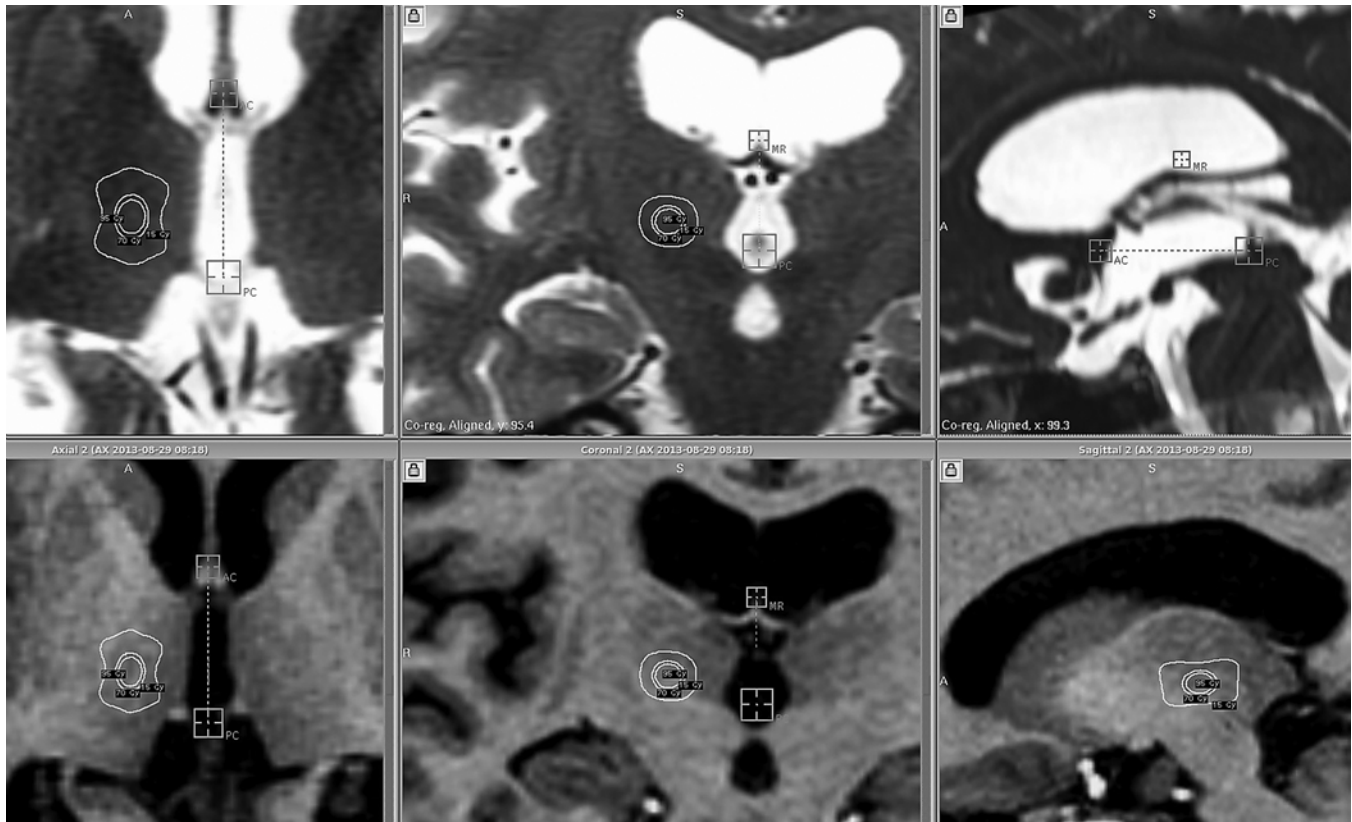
MR images showing target localization of the VIM.
